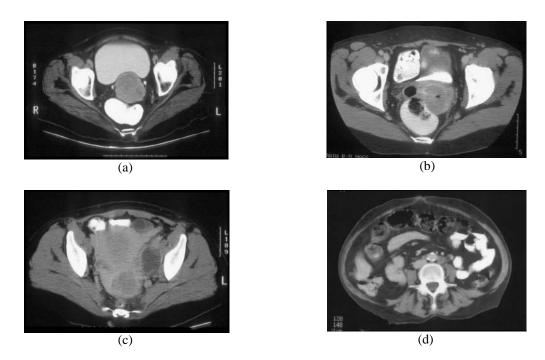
Cervical cancer's CT Images (a) STAGE-1, (b) STAGE-2, (c) STAGE-3, (d) STAGE-4
